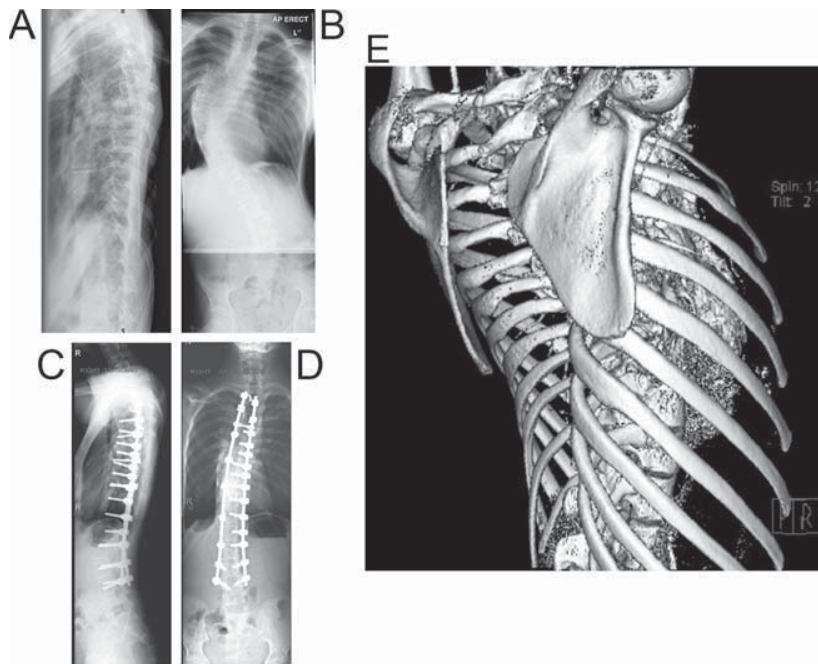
Preoperative lateral (A) and AP (B) radiographs of case 2. The preoperative thoracic deformity is also demonstrated on CT reconstruction (E). Postoperative lateral (C) and AP (D) radiographs show the position of the correction after posterior spinal fusion.
